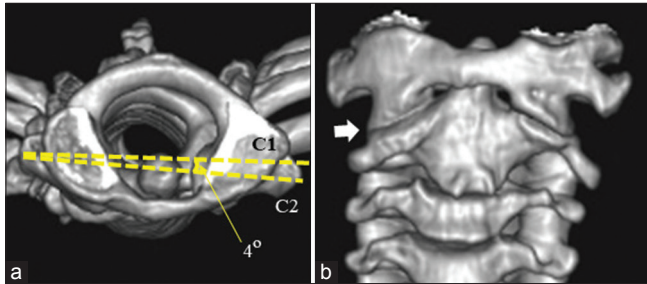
Two months after closed reduction and halo fixation, three-dimensional computed tomography in the axial (a) and anterior (b) views shows persistent C2 facet deformity (arrow), but cervical posture appears to have returned to a neutral position.
